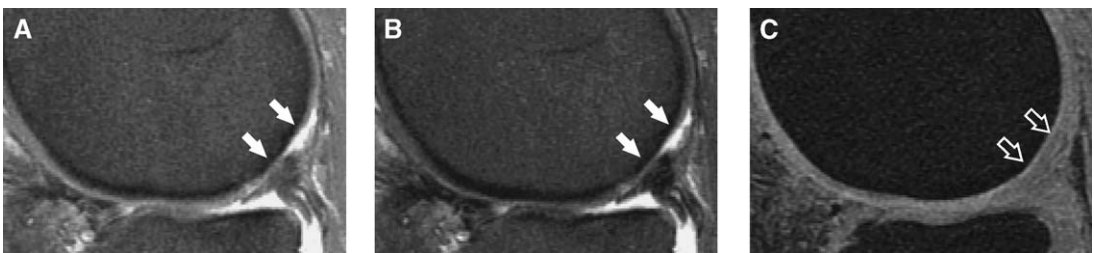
Poor delineation of cartilage defect on three-dimensional SPGR sequence. MR images in the same patient seen in Fig. 2. Sagittal short TE FSE image (A) and long TE FSE image with fat suppression (B) show large, and in some areas full-thickness, cartilage defect (arrows) in the central and posterior regions of the lateral femoral condyle. (C) Although sagittal fat-suppressed three-dimensional SPGR image can demonstrate the cartilage defect, the margins are not well defined, particularly posteriorly (open arrows). The full-thickness cartilage defect was confirmed at arthroscopy. (From Yoshioka H, Stevens K, Genovese M, et al. Articular cartilage of knee: normal patterns at MR imaging that mimic disease in healthy subjects and patients with osteoarthritis. *Radiology* 2004;231:31–8; with permission.)
